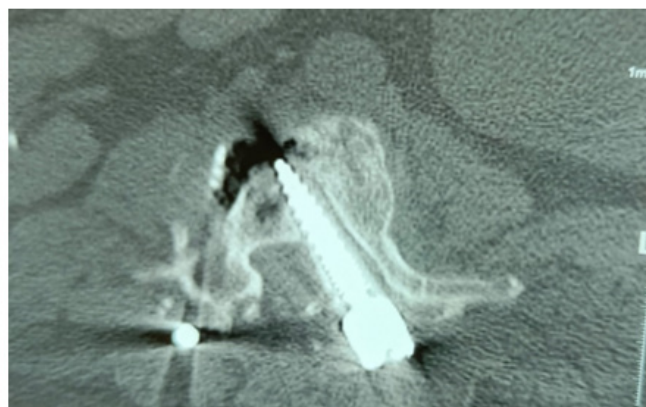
Postoperative radiograph of initial osteosynthesis.
